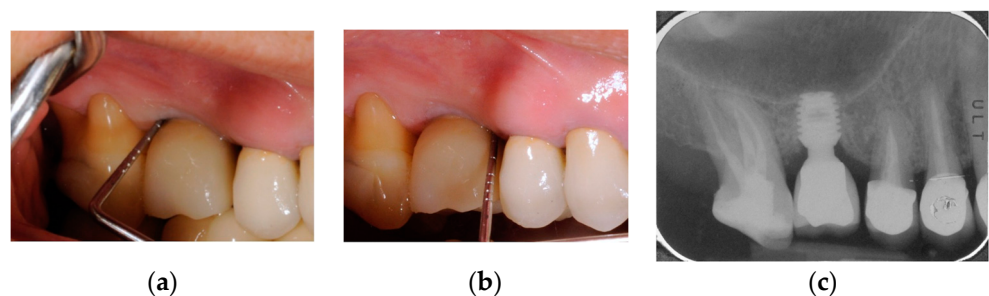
Clinical photographs obtained after 3 years from surgery time: see stable soft tissue conditions with absence of bleeding and decreased PPD (a,b). A radiograph was obtained after 3 years from surgery time: see bone gain (c).
